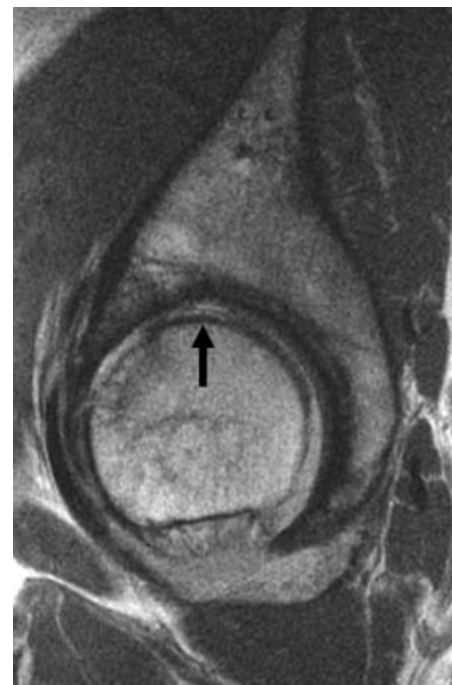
Sagittal MR image of a 45-year-old man with chronic femoroacetabular impingement demonstrates actively delaminating cartilage over the femoral head (arrow) and adjacent subchondral collapse.
